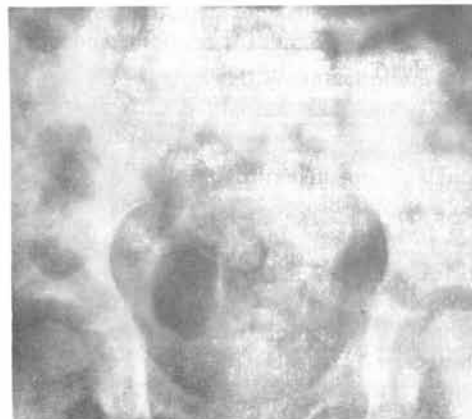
Same patient as in Fig 6 "Blow out" and radiograph of the hip.
